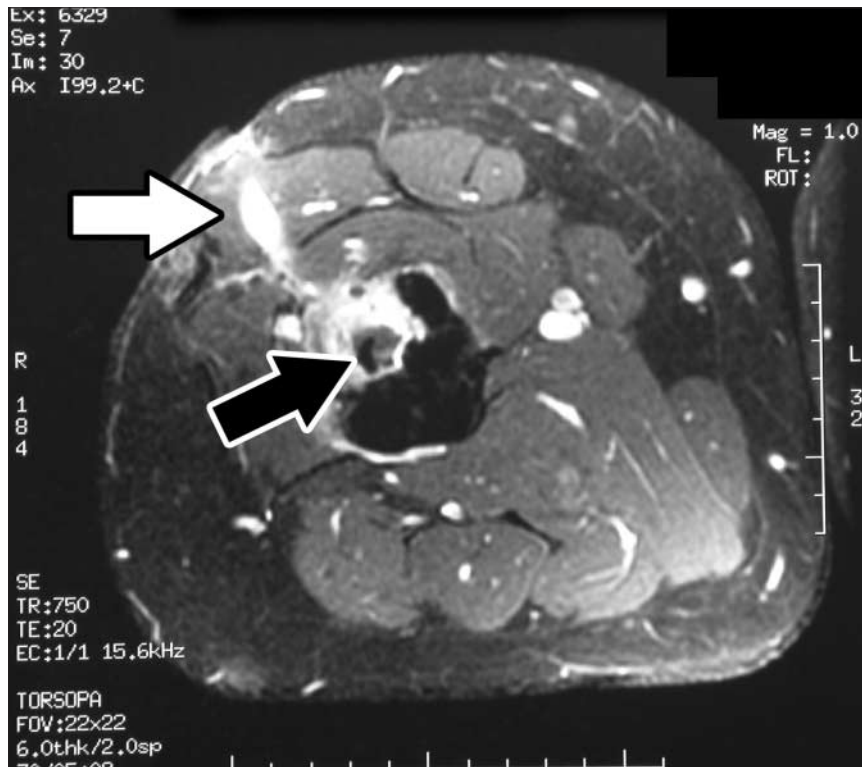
T₂-weighted, gadolinium-enhanced axial magnetic resonance image of the right femur. The black arrow shows the sequestrum and the white arrow shows the sinus tract leading to a periosteal abscess, which is highlighted by gadolinium enhancement.
